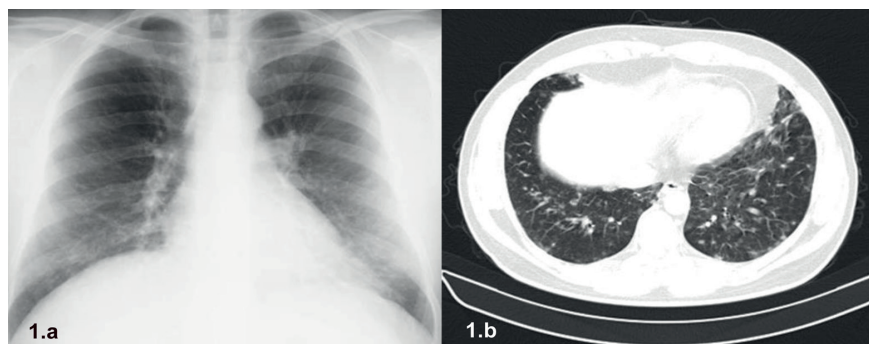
a Chest X-ray: bilateral micro-nodular alveolar infiltrates, predominantly in inferior areas; b Chest CT-scan: same aspects.
